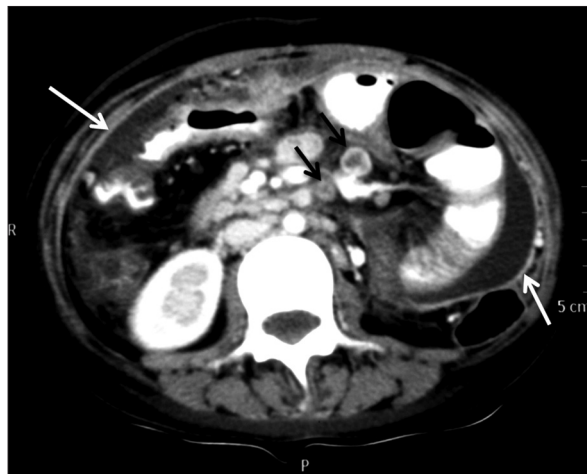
Abdominal cocoon due to tuberculosis in 35-year-old female - axial contrast-enhanced computed tomography showing enhancing fibrotic membrane (white arrows) with ascites and focal dilatation of jejunal loop and necrotic mesenteric lymph nodes (black arrow)
